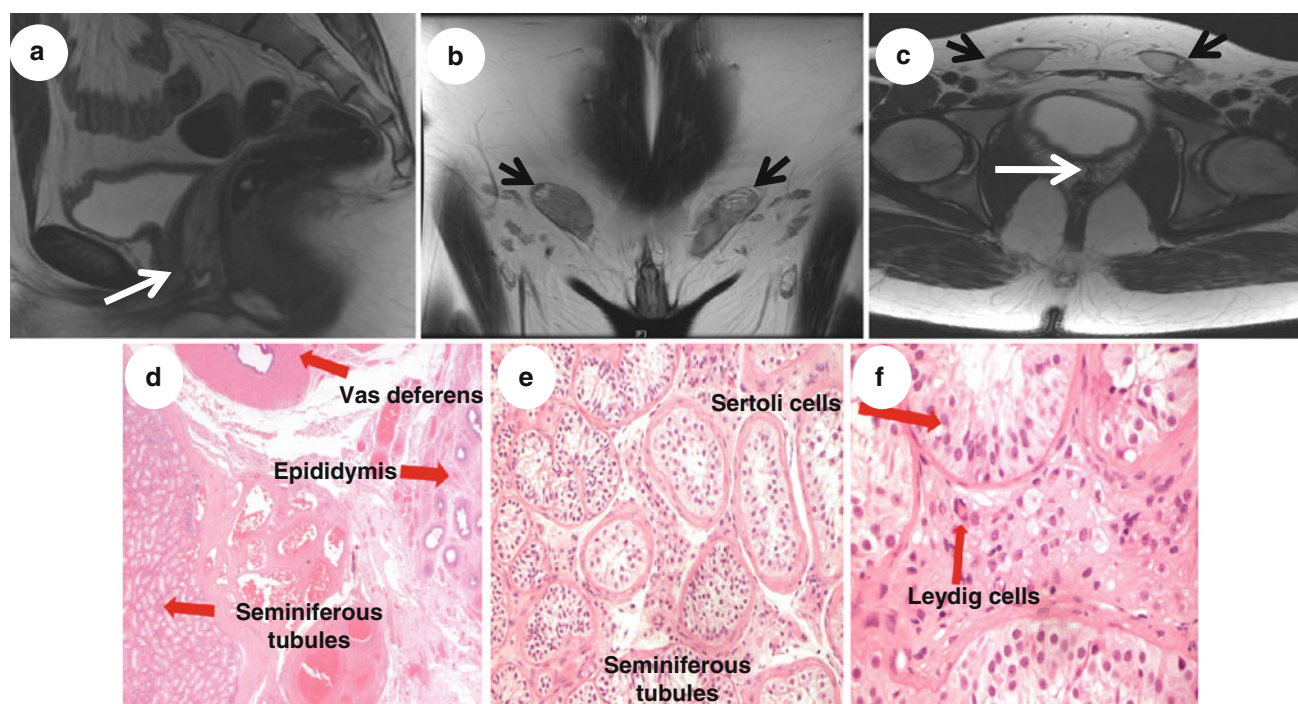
a Sagittal, b Coronal and c Axial T2-weighted images of pelvis demonstrate an absent uterus and upper 2/3 of the vagina. Atrophy of the lower third of the vagina (white arrows a, c) is also seen. Both gonads are present and lie in the inguinal canals (black
